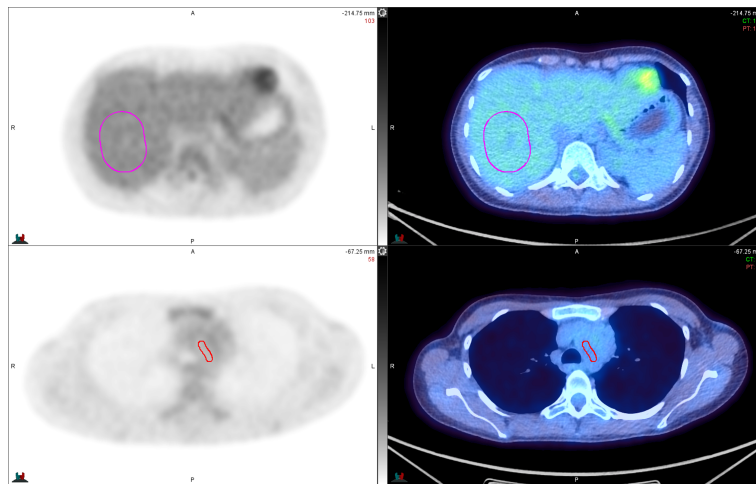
Axial PET and fused PET-CT slices showing the placement of the 2D ROIs used to measure the  $SUV_{max}$  in the liver (top) and MBP (bottom).
